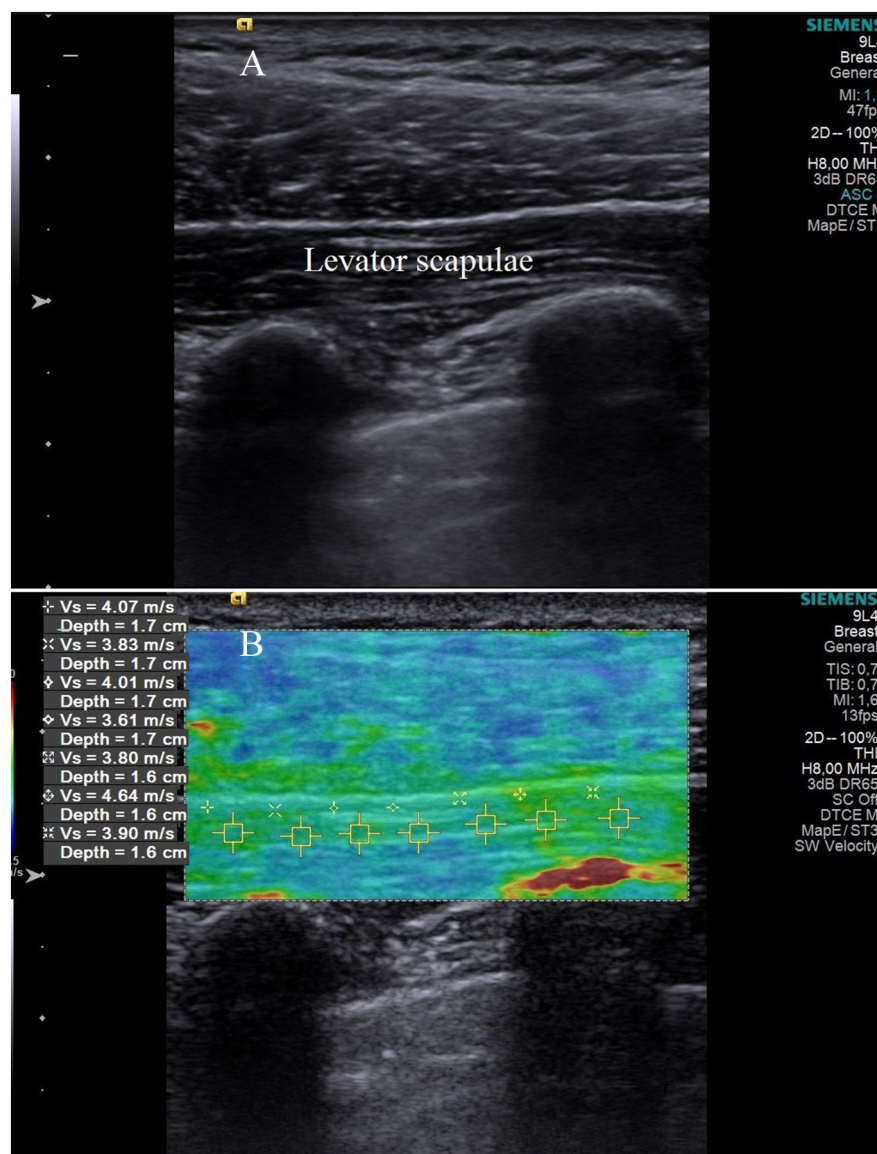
Two-dimensional ultrasound of the levator scapulae muscle (A). Color map shear wave elastography image of the sternocleidomastoid muscle in the longitudinal plane (B). Ranges of image were placed in the muscle, and corresponding shear wave velocity (m/sec) values were recorded. The shear wave velocity of the tissues increases in the order of blue-green-red color-coded areas.
